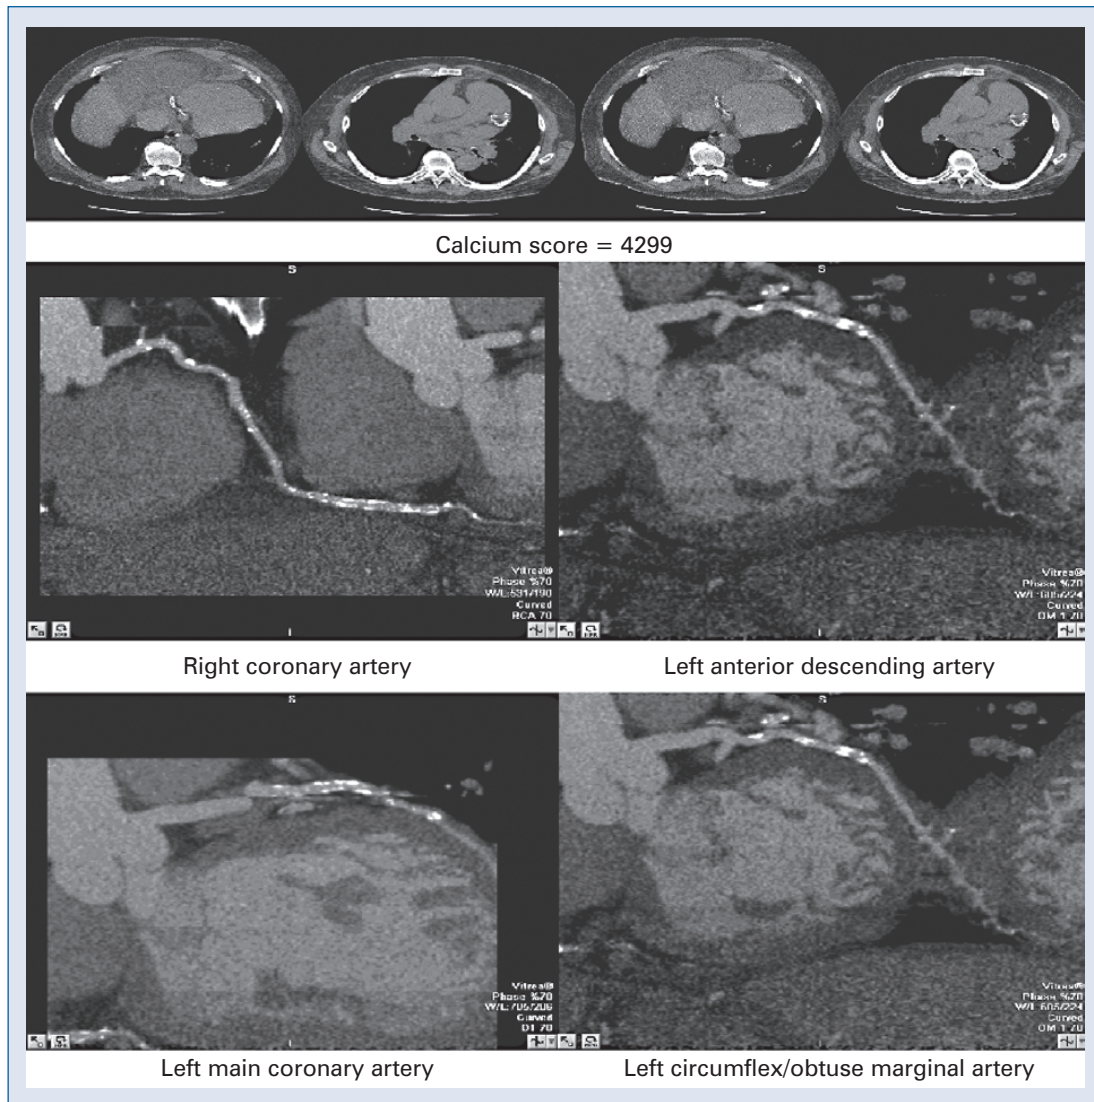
D. A 58 year-old male with ejection fraction of 40%, moderate-severe mitral regurgitation on dobutamine echocardiography which was negative for ischemia referred for catheterization given significant mitral regurgitation. Research CCTA in this patient shows markedly elevated calcium but no obvious obstructive coronary angiography on CCTA confirmed by cardiac catheterization which showed minimal coronary luminal irregularities despite substantial coronary calcification.
